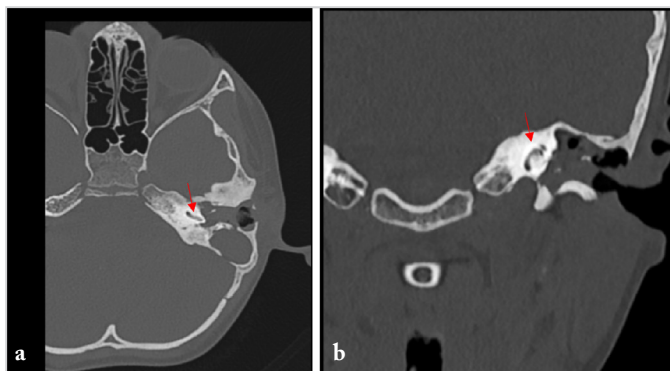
a) HRCT of temporal bones with axial cuts showing ossification within basal turn of left cochlea (red arrow), b) Coronal cut showing higher degree of ossification of middle turn and apical turn of left cochlea compared to basal turn (red arrow)
